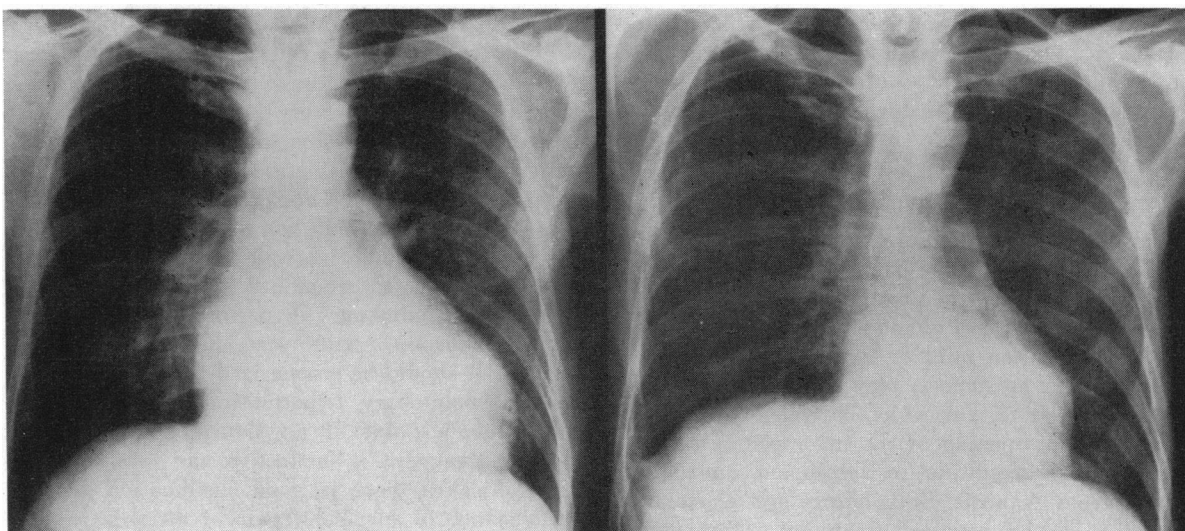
Anteroposterior roentgenogram of a patient with severe mitral regurgitation: left, before; right, after mitral valvular repair.
